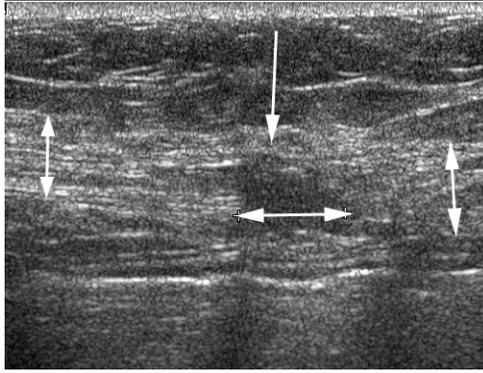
Partial recurrence of an incisional hernia 2 years after a three-layered direct suture repair. Transverse midline sonogram shows the partial defect (horizontal double arrow) and no protrusion of a hernial sac. The anterior rectus fascia is intact (vertical arrow). Vertical double arrows indicate the rectus muscles.
